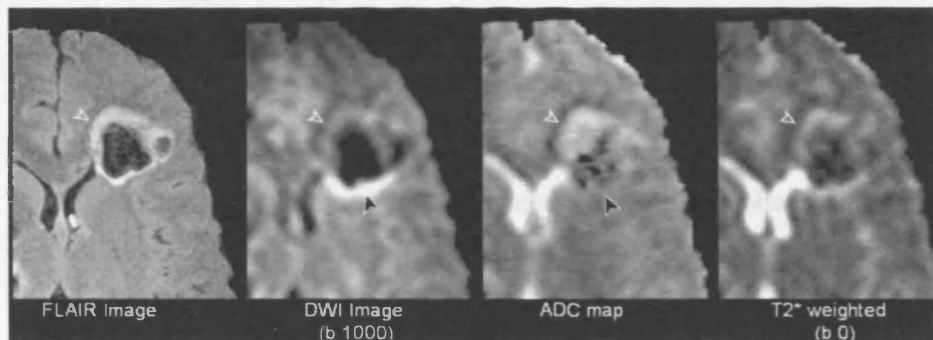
Detail from figure 36. Showing T2* dark back on T2* weighted image which can also be seen on DWI (co-localised open whiter arrowheads). Inspection of the area on DWI marked by the open white arrowhead, without consideration of T2* effects, would lead to the belief that diffusion in this area was increased whilst in fact the co-localised arrowhead on the ADC map shows the opposite. T2 shine-through is also present on the DWI where the ADC values are in fact normal, co-localised black arrowheads on the DWI and ADC map.
